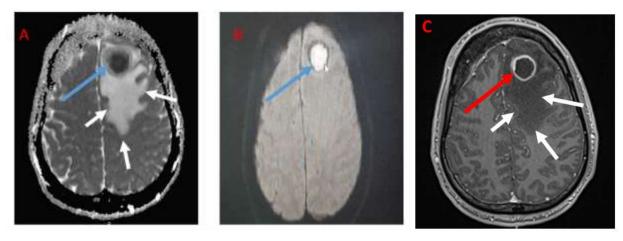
Magnetic Resonance Imaging (MRI) (A) Axial section of ADC weighted magnetic. And (B) DWI -weighted magnetic resonance imaging showing: diffusion restriction (blue arrows)
